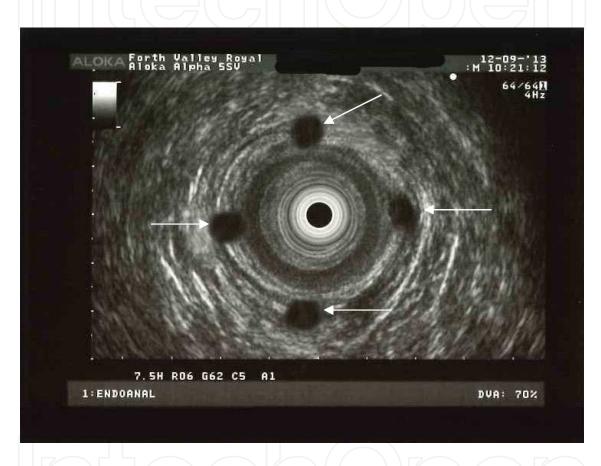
Endoanal ultrasound scan at 6 weeks following the implantation of four Gatekeeper prostheses (arrows) in a 72 year old male with idiopathic passive faecal incontinence.
